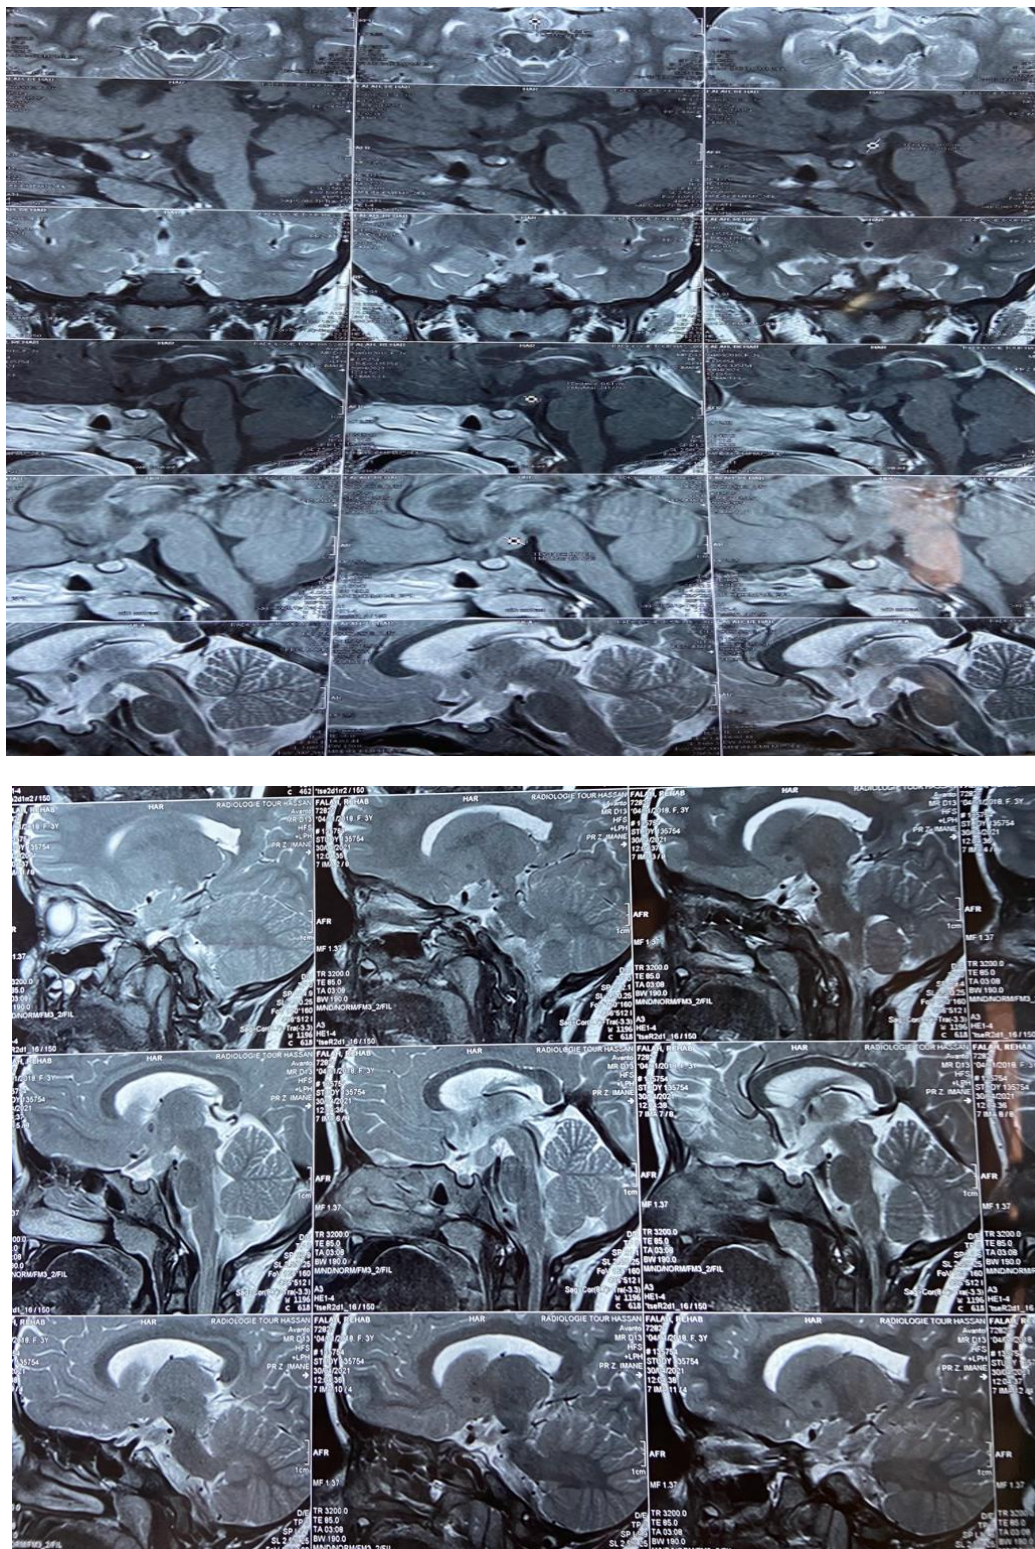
MRI image of hypothalamic hamartoma
